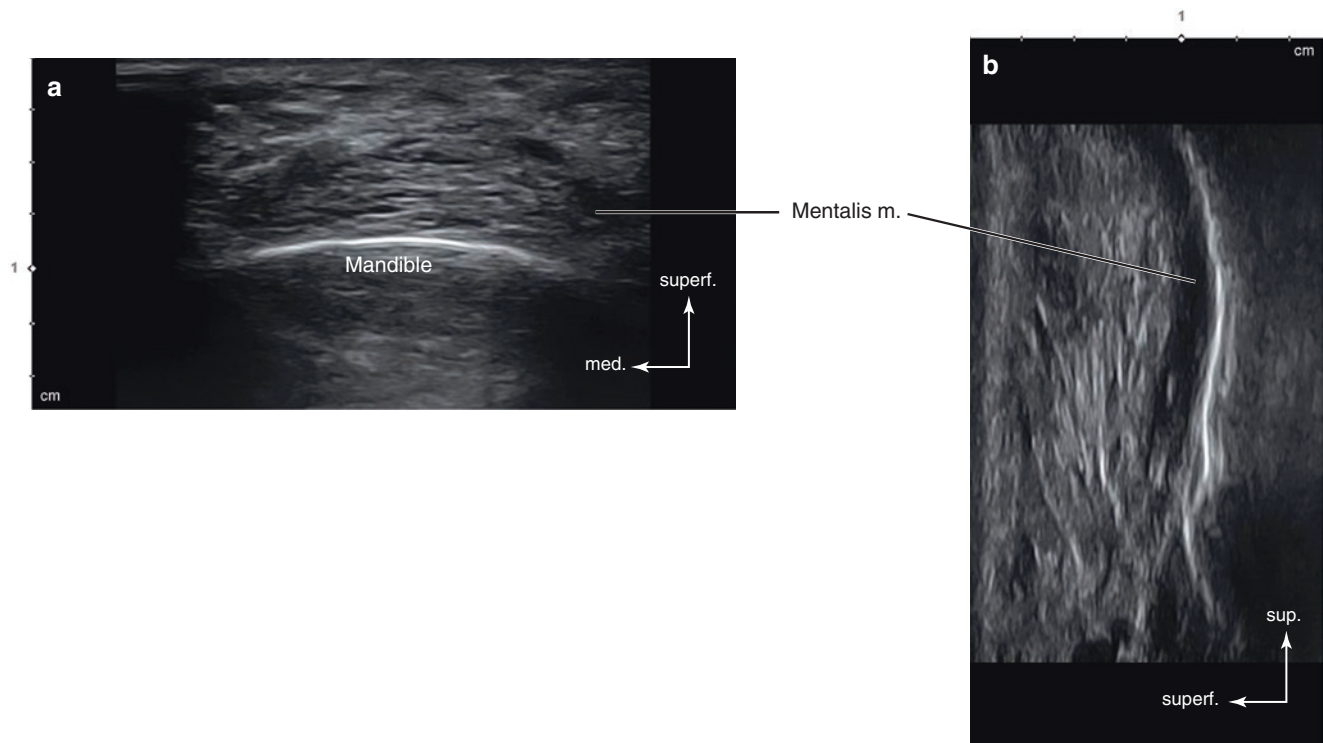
Ultrasonography of the mentalis muscle. (a) B mode (transverse view, 15 MHz by linear transducer) and (b) B mode (sagittal view, 15 MHz by linear transducer). (Published with kind permission of © Ji-Soo Kim 2020. All Rights Reserved)
